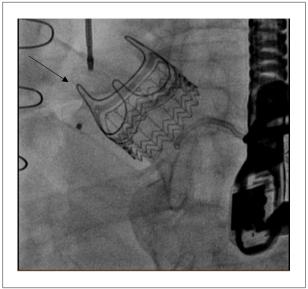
Normally positioned biologic aortic prosthesis associated with the presence of the plug, with significant reduction of the shunt through the fistula evaluated by in-room echocardiography.
